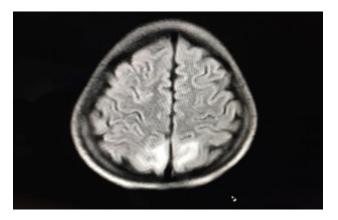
Biateral hyper intense signal in occipitial region on T2 weighted MRI.
